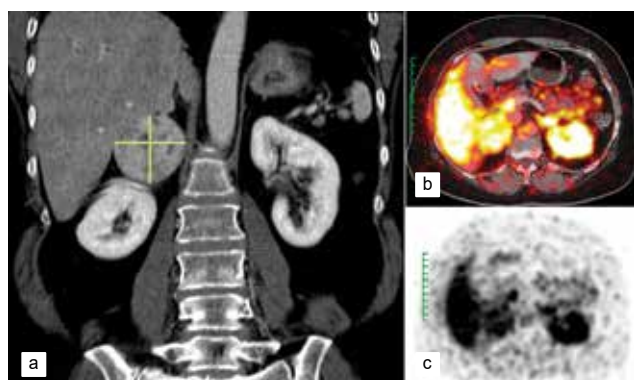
Right adrenal pheochromocytoma (marked in green) as seen in a) CT image, b) PET image and c) PET DOTATOC image.
